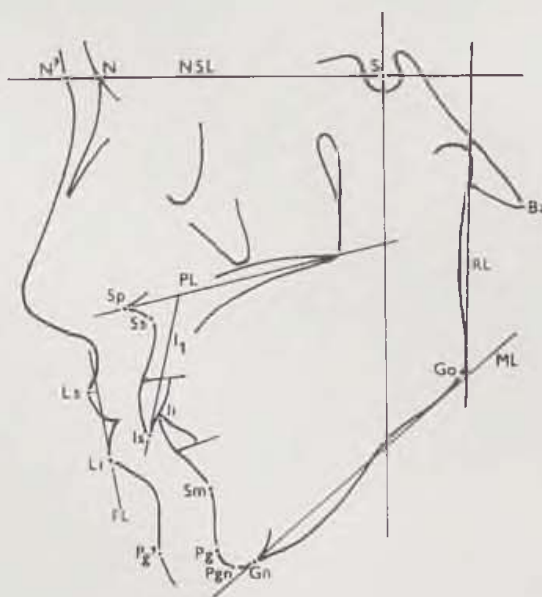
Cephalometric points and reference lines used for the assessment of X-ray films
